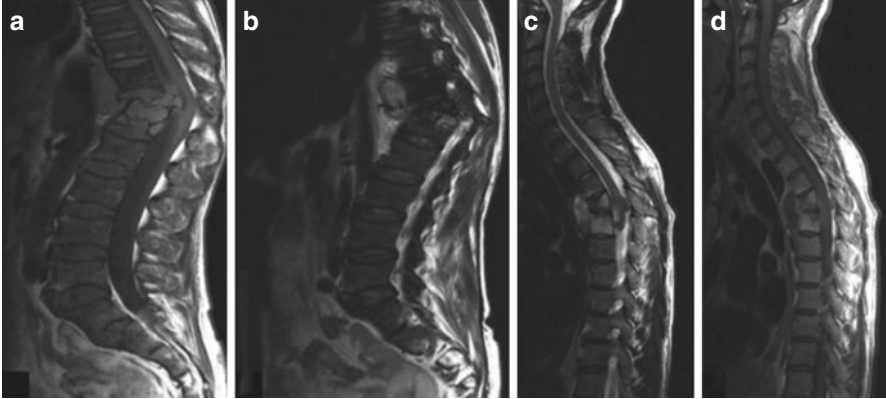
MRI of an HIV-negative (a) and (b) and an HIV-positive (c) & (d) patient with spinal TB: The HIV-negative patient shows greater vertebral body destruction (T11/T12) and kyphosis. The HIV-positive patient shows significantly less vertebral body destruction and kyphosis. (Reproduced from Anley et al. [44])
